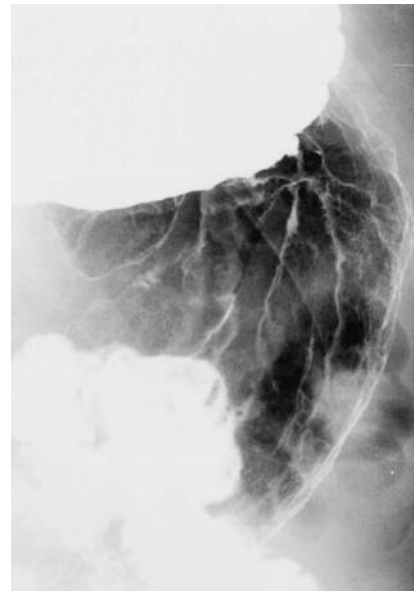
Case 1. Converging folds were found on the posterior wall of the gastric body on a X-ray examination, and were assumed to be indicative of a IIc-type early gastric cancer
